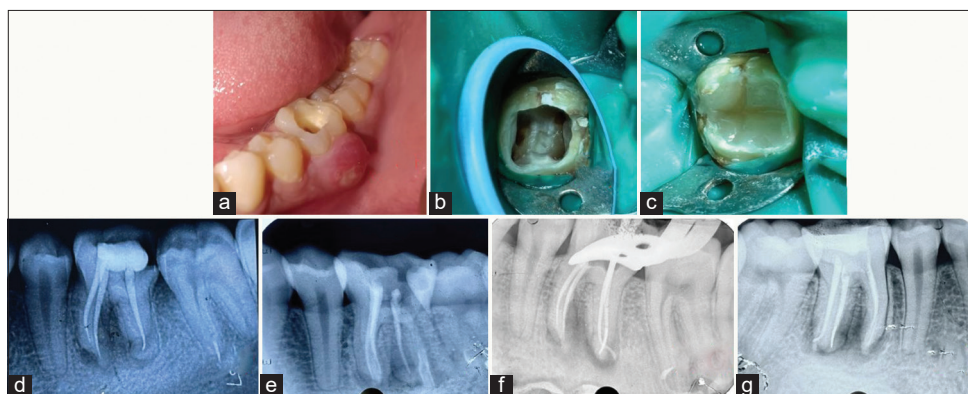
(a) Clinical picture showing gingival swelling; (b) access cavity showing an extra canal; (c) post endodontic restoration; (d) pre-operative radiograph; (e) radiograph taken from the mesial angulation showed missed distal canal; (f) master cone radiograph; (g) obturation (case 3)
